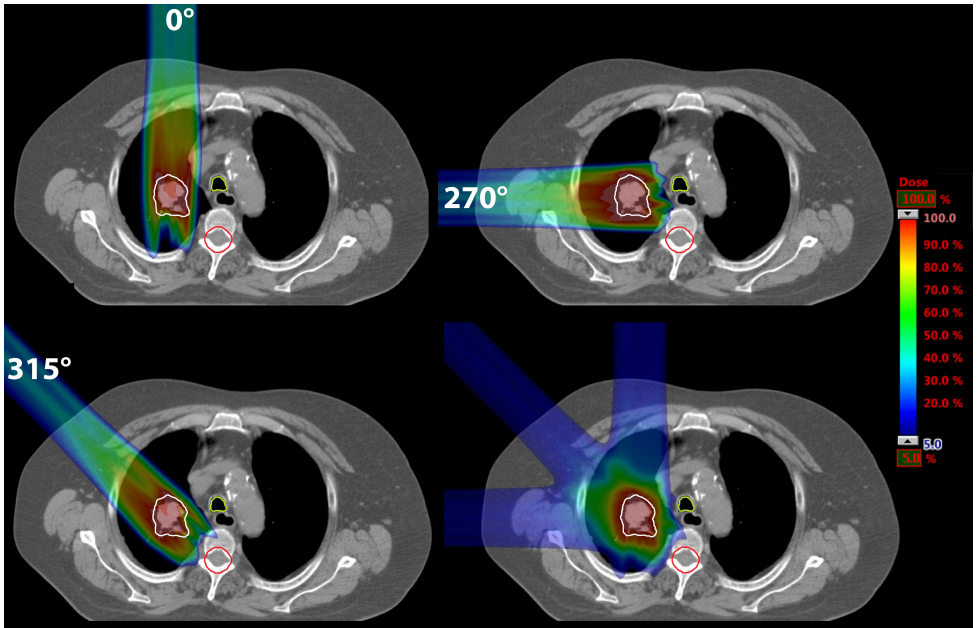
CT slices of one exemplary patient: for the beam directions 0° , 270° , and 315° plans were optimized individually consisting of one single field. On the bottom right the sum of these plans is shown. The CTV is marked in white, trachea in light green and spinal cord in red. On the right a color bar is given indicating the relative dose. Figure taken from (Baumann et al. 2019b).
